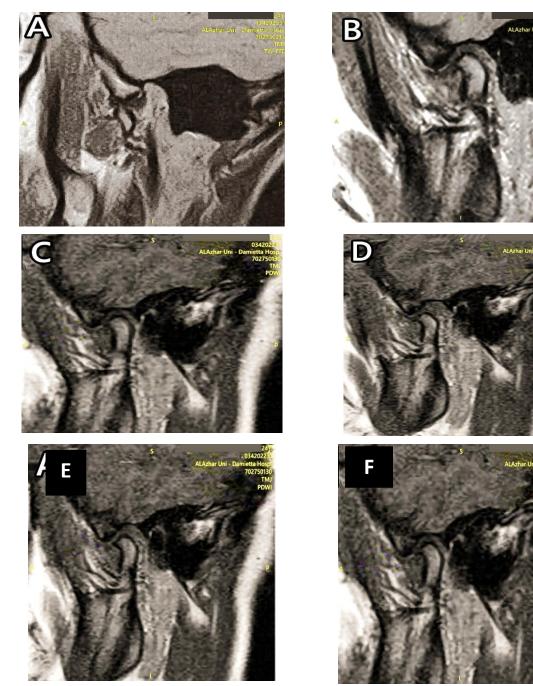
A 24-year-old female patient presented clinically by left temporomandibular joint pain and clicking. Static MRI [A-B images]: sagittal PDWI MRI of right TMJ in open [A] and closed [B] mouth position revealed that the posterior band of the articular disc is seen anterior to the condyle in closed mouth view with normal position in open view. Thickening of the superior layer of retrodiscal tissue was noted giving pseudo disc sign. Dynamic MRI [C-F images]: dynamic MRI study of right TMJ revealed anteriorly displaced disc in relation to condylar head with reduction on opening of the mouth associated with normal condylar translation. Diagnosis: A case of right anterior disc displacement with reduction
